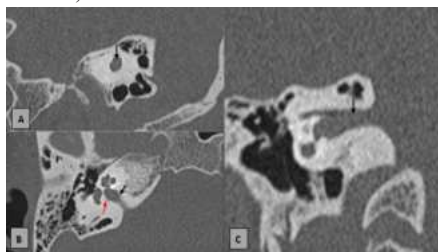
HRCT temporal bone, bone algorithm; A. sagittal; B. axial at the level of lower compartment of IAC and C. coronal sections, showing IAC (black arrow), canal for cochlear nerve (white arrow) and singular canal (red arrow). Variability in both morphology and morphometry of neural foramina is a common observation within the normal population, differing not only from their contralateral counterparts but also among individuals. This study aimed to investigate this phenomenon further. In clinical practice, the analysis of skull base foramina plays a crucial role in identifying abnormalities in size, particularly for diagnosing perineural spread and other pathologies highlighted in the literature review. While MRI is typically the preferred diagnostic imaging modality for perineural spread, certain clinical scenarios may preclude its use, as previously discussed. In such instances, CT scans become vital for detecting perineural spread, with the most commonly used sign being the widening of neural foramina. However, the absence of established normal values for neural foramina size in the literature leads to subjective assessments of abnormal widening, contributing to significant interobserver variability and potential misinterpretations.
